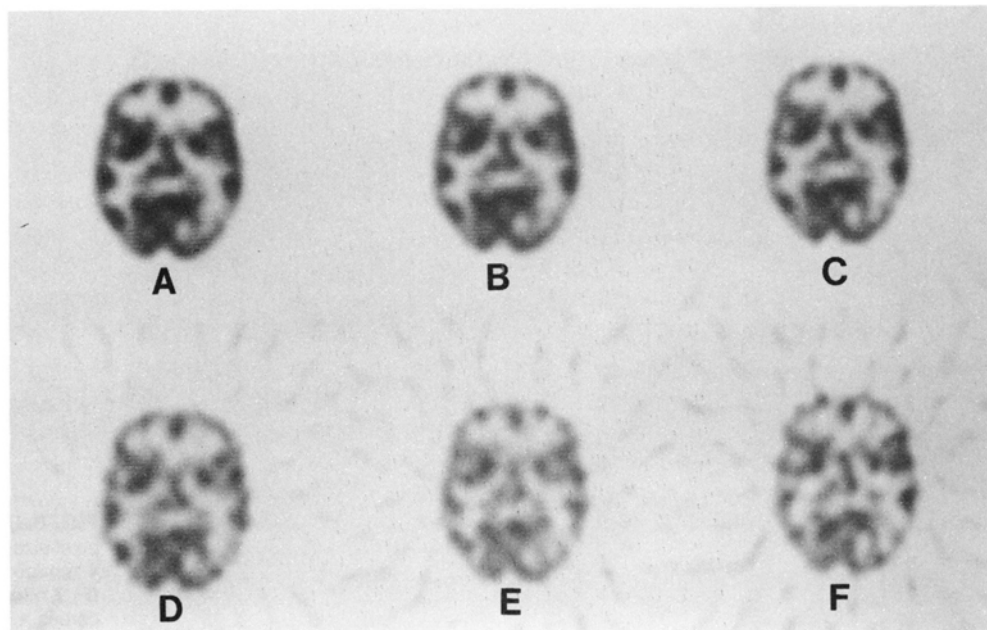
SPECT image quality as a function of number of projection views. (A) 120 projections, (B) 90 projections, (C) 72 projections, (D) 60 projections, (E) 45 projections, (F) 40 projections.
